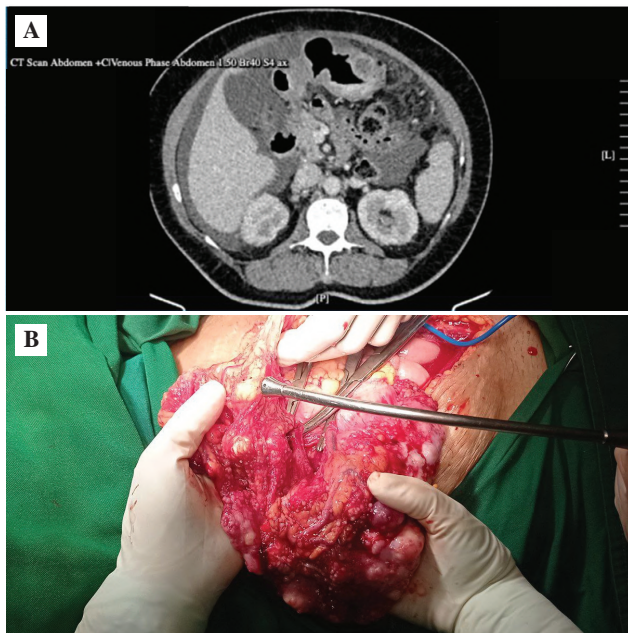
Presence of omental carcinomatosis. A: An abdomino-pelvic CT-scan showing irregular peritoneal and omental thickening with contrast enhancement suggesting an omental carcinomatosis occupying the pelvic and abdominal cavity; B: Intraoperative evaluation confirmed the presence of omental carcinomatosis.
